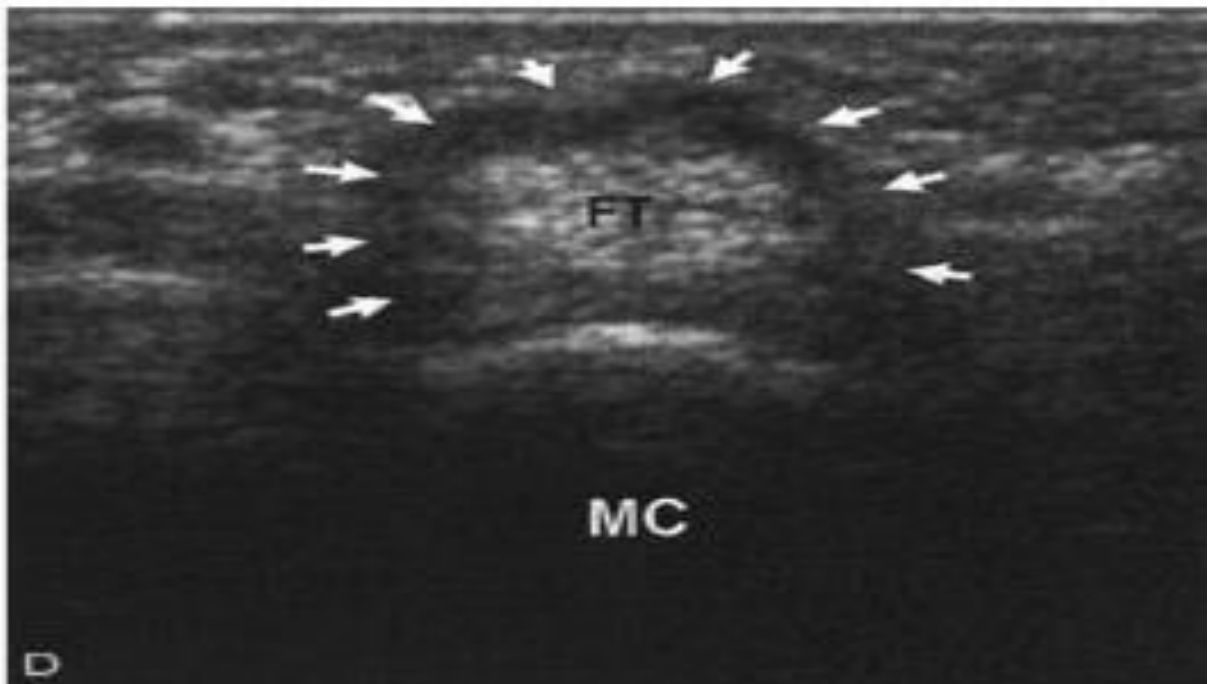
Thickened A1 pulley and Digital nerve and vessels seen on either side of tendon when keeping the ultrasound in horizontal position.
